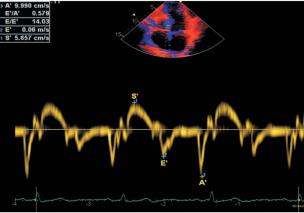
Measurement of conventional mitral inflow (left) and tissue Doppler imaging at the septal mitral annulus (right).
